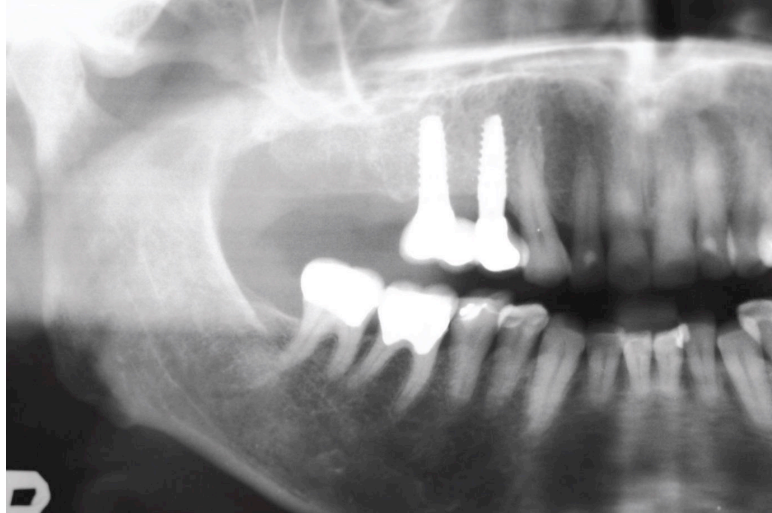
Radiograph showing stable peri-implant bone 3 months after restoration.
